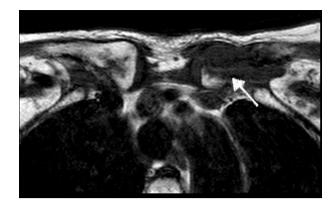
MRI of both clavicles in axial view showing the absence of marrow signal (arrow).
